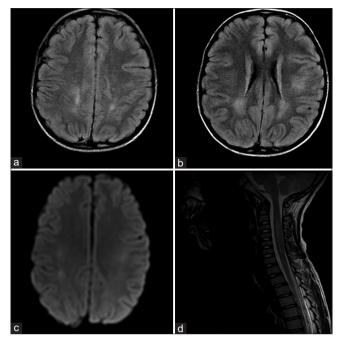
MRI of the brain (a-c) and cervical spine (d); Multiple high FLAIR signal intensities in the deep white matter of the parietal lobes (a and b) with diffusion restriction on the DWI images (c). A long segment (5–6 segments) of high T2 signal intensity occupying more than two-thirds of the cervical cord
